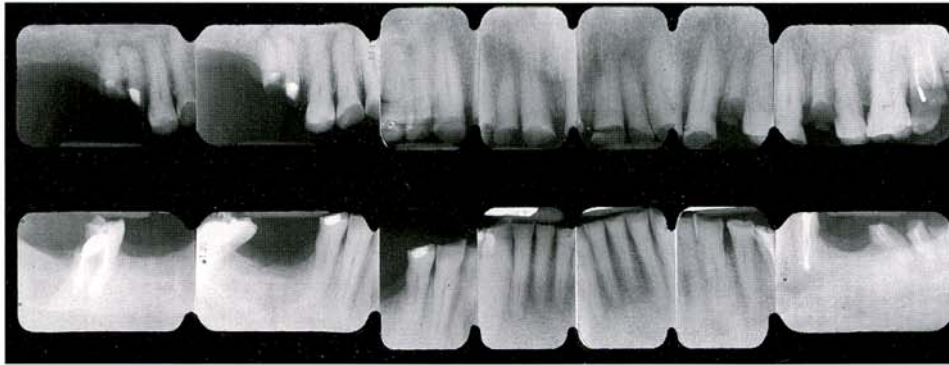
Full-mouth radiographs.
